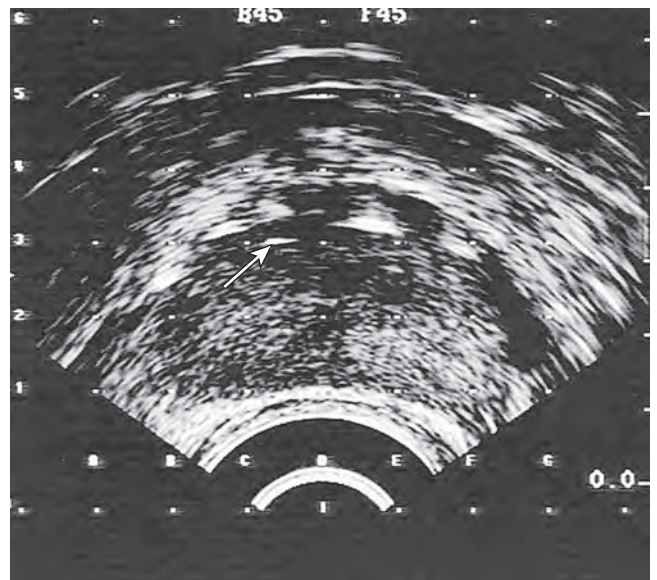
Transverse ultrasound image of the prostate. Several seeds are visible in the anterior gland. The arrow delineates the target location for the insertion of a needle.
